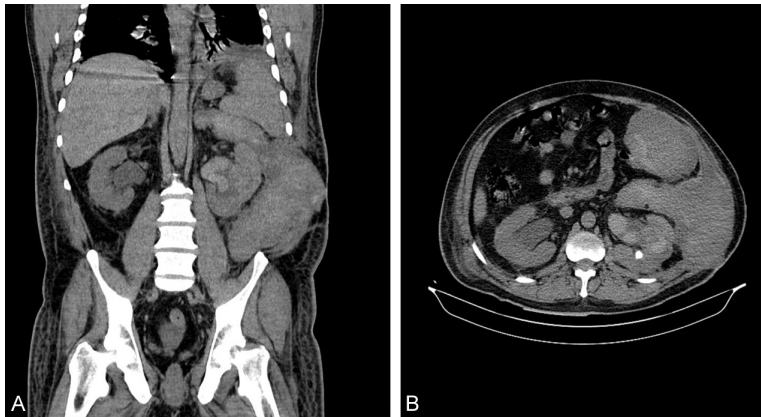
Abdominopelvic CT scan without contrast showing bilateral hydronephrosis.
